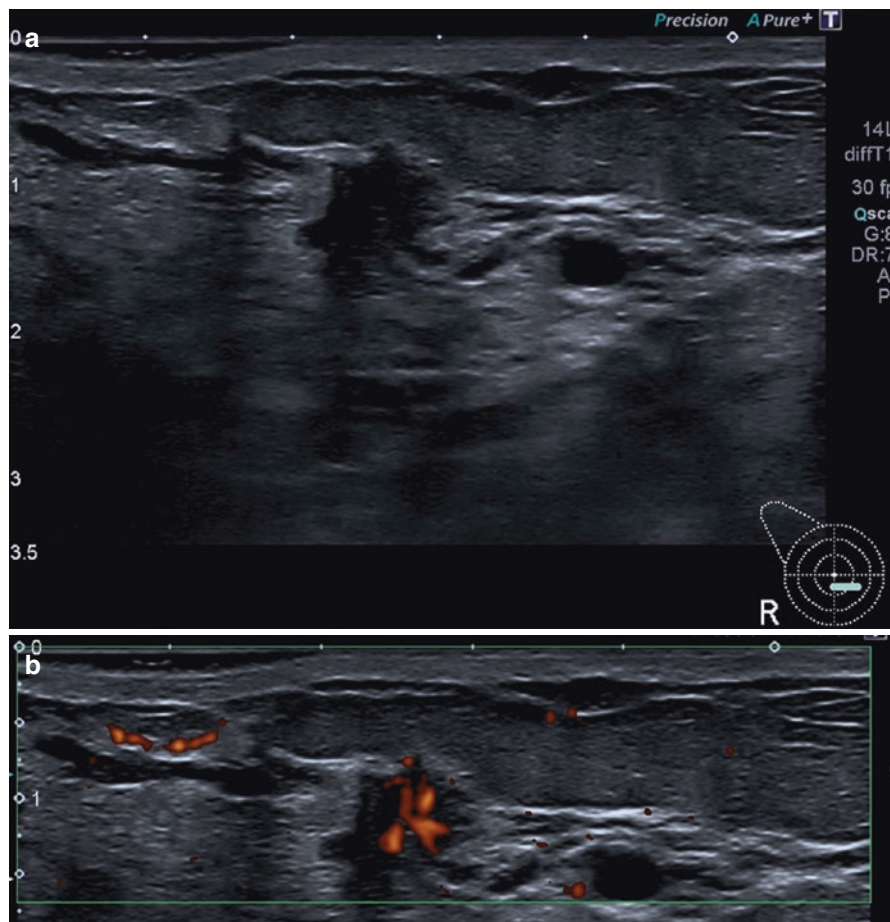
A 48-year-old patient presenting with a suspicious lesion palpated in the right breast. The ultrasound B-mode image shows an irregular, microlobulated, spiculated focal lesion measuring 1.2 cm with marked ductal dilation in the vicinity of the lesion (a). The B-mode appearance is consistent with a BI-RADS 5 lesion. Ductal dilation in the vicinity of the lesion may indicate a DCIS component. There is ample perfusion of the lesion and a vessel entering the focal lesion perpendicularly (b). TDI shows complete absence of color pixels in the lesion, consistent with incompressibility (c). Both techniques confirm breast cancer. The fat-to-lesion strain ratio (FLR) is only slightly elevated at 1.62 (d). Shear wave elastography (SWE) shows faster transmission of signals through the breast lesion (e), which is reflected in an increase in the SWE ratio (f)
